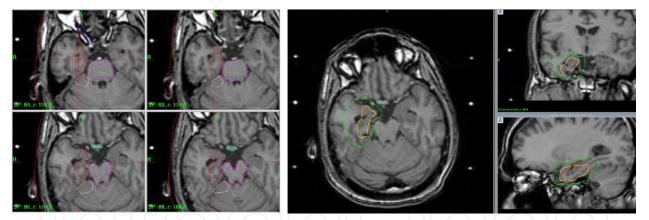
(left) MR image showing target volume (red), brainstem (pink), and optical chiasm (blue). The target volume consists of the amygdala, anterior hippocampus, and parahippocampal gyrus. (right) A typical dose distribution is shown with the prescription (24 Gy) isodose line shown in yellow and the 8 Gy isodose line in green.
